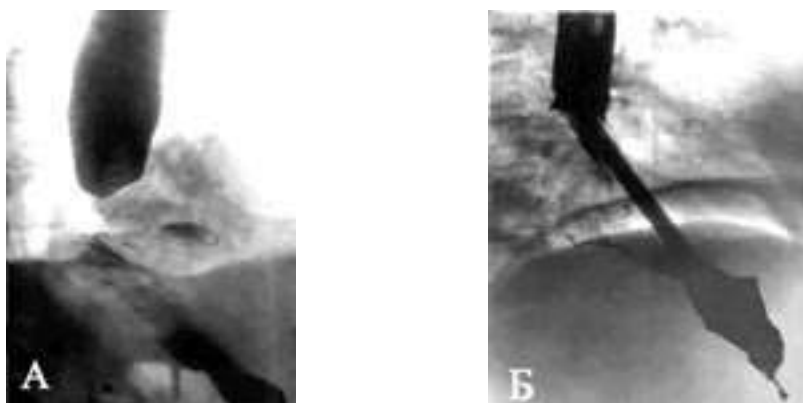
Radiographs and endophotos of rigid (A) and self-expanding (B) stents
